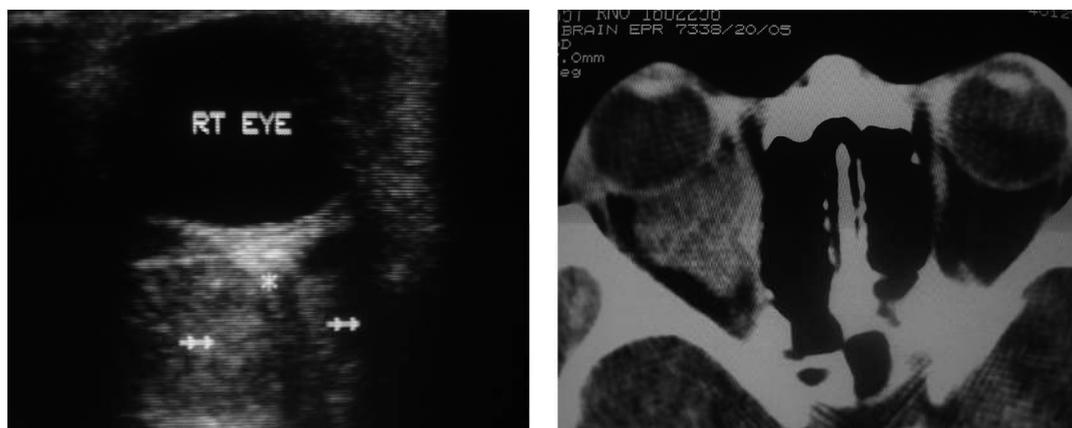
Orbital pseudotumor with bulky extraocular muscles compressing central optic nerve on USG (left) and inhomogeneous soft tissue mass on CT (left)
